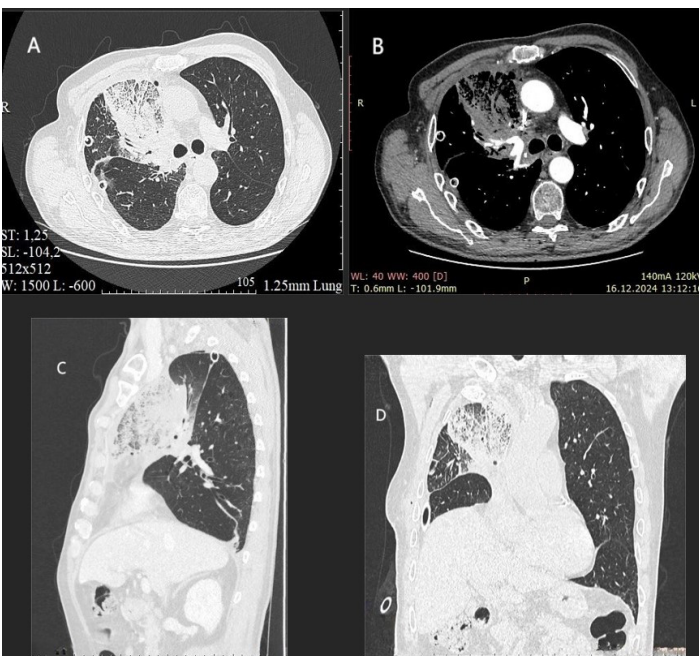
Contrast-enhanced CT on postoperative day 3 following surgery. Axial section with lung window (A), mediastinal window (B), sagittal section (C) and coronal section (D) demonstrates consolidation, ground-glass opacities with an interlobular septal thickening in the middle lobe.
